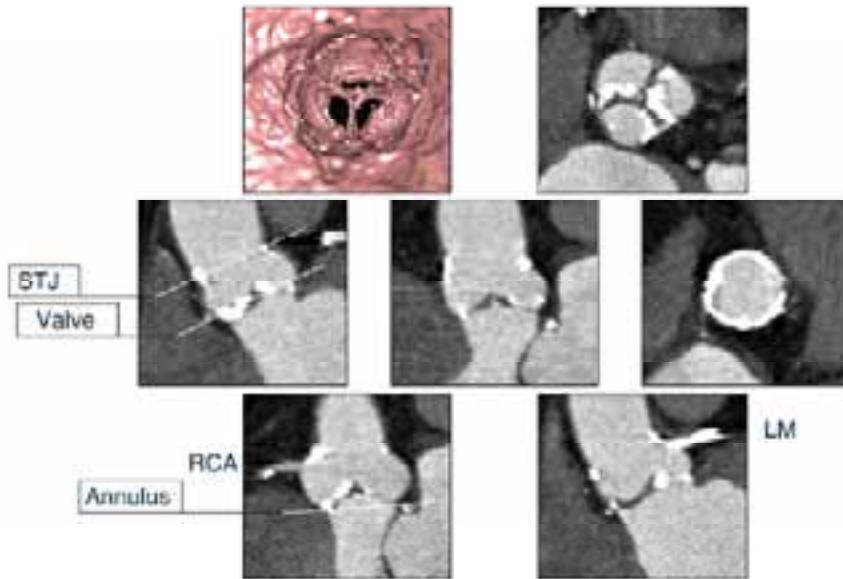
This figure shows computed tomography images of the calcified leaflet margins of a stenotic aortic valve (upper right panel), the sinotubular junction (STJ) with dense, circumferential calcification (right middle panel), and the level of the aortic annulus (left lower panel). The ostia of the coronary ostia (RCA, right coronary artery; LM, left main) are seen in the lower panels.
